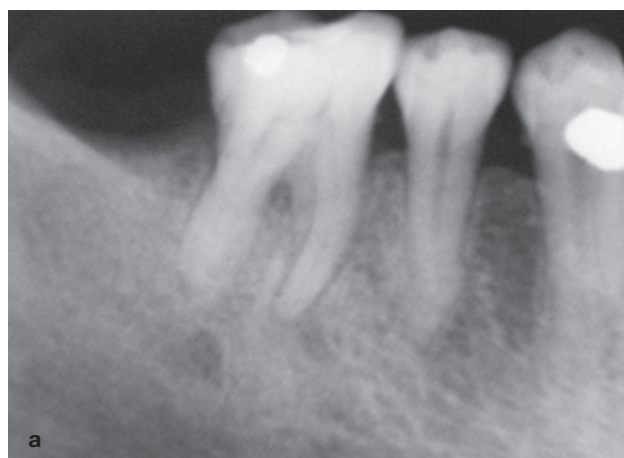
Mandibular first right molar with five root canals (case one). (a) Preoperative radiograph. (b) Radiograph with five gutta-percha points. (c) Postobturation radiograph. (d) One month follow-up.
